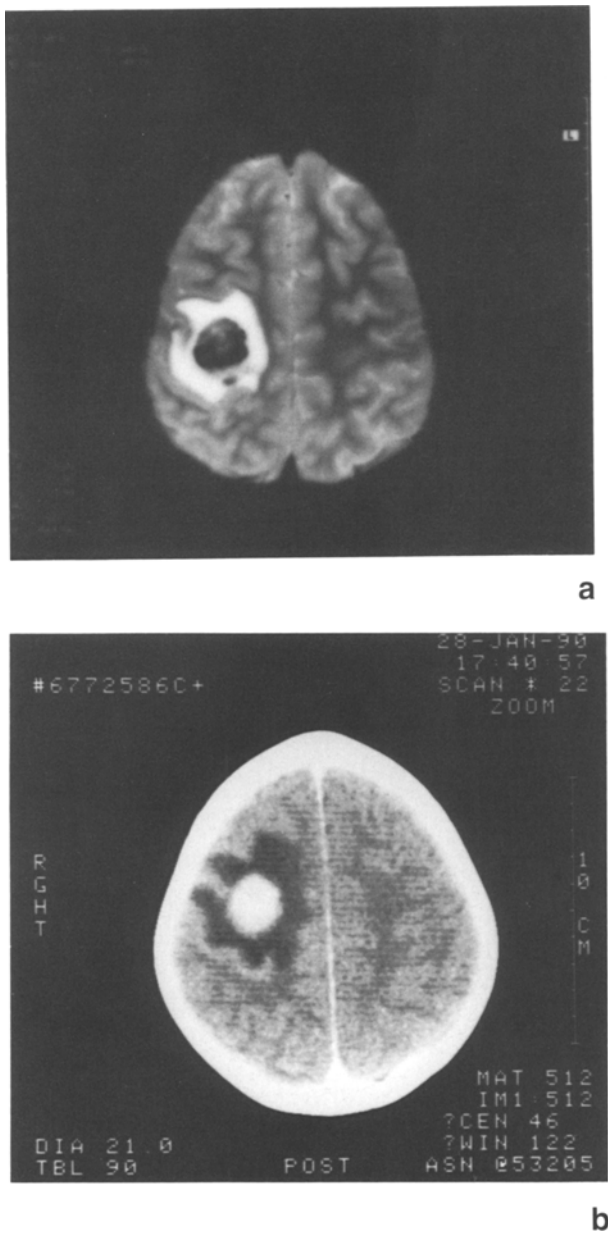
(a, b) The T-2 weighted axial (a) MR and contrast enhanced axial CT scan (b) images of brain show the single metastatic lesion of the hepatocellular carcinoma in the right parietal area
